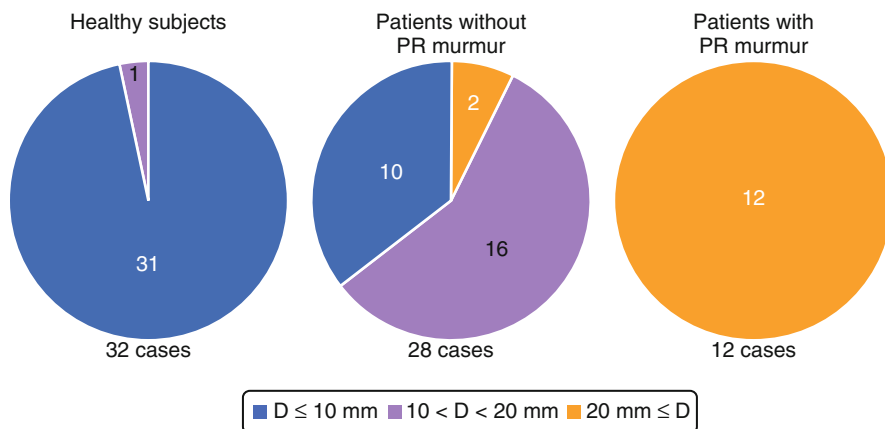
Compared to healthy patients and patients without a pulmonary regurgitation murmur, the murmur of pulmonary regurgitation is seen when Doppler evidence of a larger volume and velocity of regurgitation (at least 20 mm on color Doppler) is seen. *D*: right ventricular diastolic pressure (Used with permission from Takao et al. [4])
